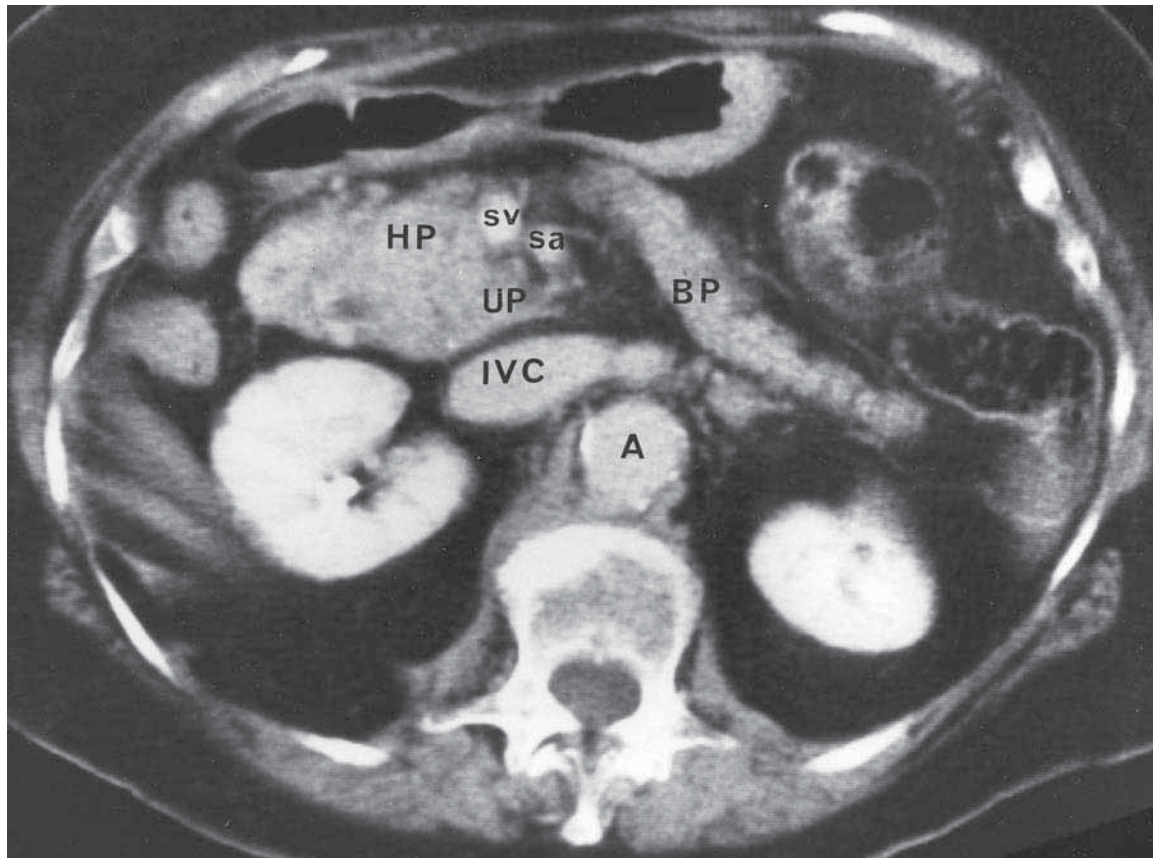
CT Passing through the Level of the Second Lumbar Vertebra in a Normal Abdomen
